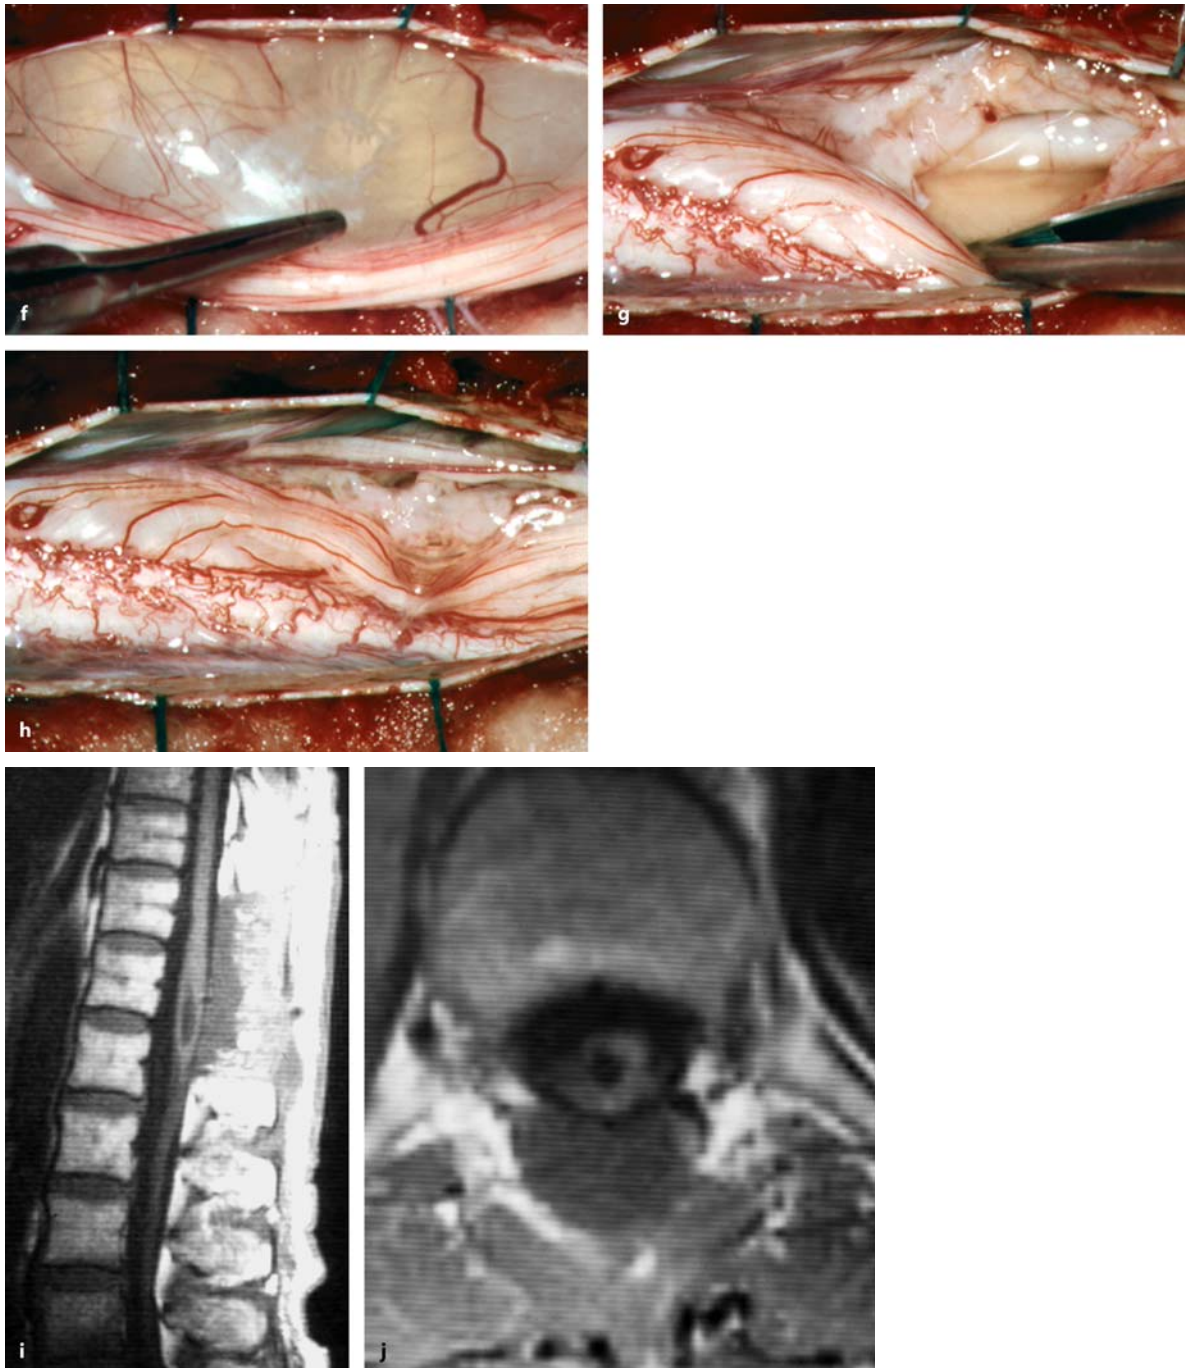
(Continued) Sagittal (a) and axial (b) T2-weighted MRI scans of an ependymal cyst at L1–L2 and an associated tethered cord in a 58-year-old woman with an 18-month history of progressive paraparesis and pain, but preserved sphincter functions. c This intraoperative view was taken after dura opening and demonstrates slight arachnoid adhesions and thickening. d After arachnoid opening, the cyst was almost visible through the pia mater and thinned out posterior tracts in the midline (arrowhead). e The thickened filum terminale is displayed and clearly distinguishable by its brighter color compared to neighboring nerve roots. The filum was then isolated (f), coagulated, and cut (g) to untether the cord. h Finally, the ependymal cyst was opened in the midline. A wide fenestration was not performed to avoid damage to white matter tracts. Postoperatively, the patient showed improvement of walking, sensory disturbances, and pain
